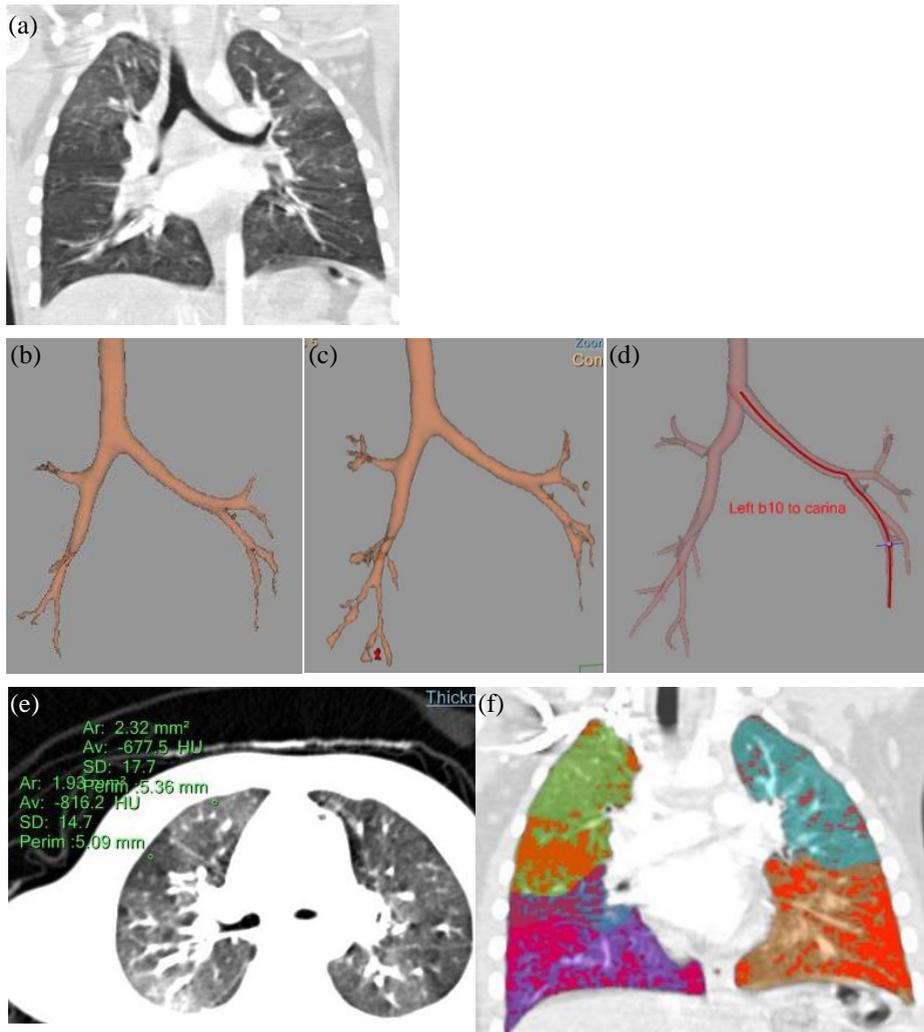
A representative case of a successful quantitative analysis in a four-year-old girl with post-infectious bronchiolitis obliterans. (a) The coronal reconstructed CT image demonstrates bronchial wall thickening with mosaic attenuation in bilateral lungs. (b and c) Automatic airway segmentation (b) and subsequent manual editing (c) reveals all segmental bronchi in bilateral lungs. (d) Each segment is labeled. (e) Small regions of interest are drawn at normal and air-trapping lung parenchyma to calculate individualized threshold value of emphysema. (f) Lung parenchyma area with CT attenuation value lower than the calculated threshold is masked with orange color.
